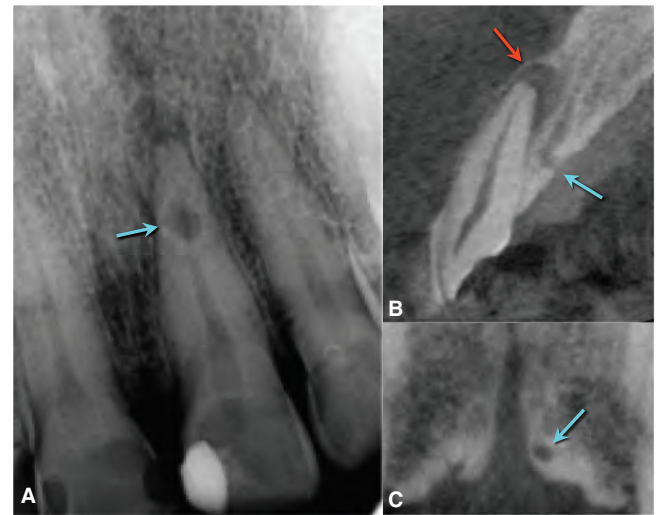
Canalis Sinuosus* mimicking the appearance of root resorption. A. Periapical radiograph of a maxillary left central incisor with recurrent caries and pulpitis showing apical radiolucency, and what appears to be root resorption in the apical third of the root (blue arrow). B. CBCT sagittal reconstruction showing the same tooth with an apical lesion (red arrow), however, without evidence of the root resorption. Instead, *canalis sinuosus* was detected. *Canalis sinuosus* is a normal anatomic variation of the anterior superior alveolar neurovascular bundle with rare manifestations in the anterior maxilla. C. CBCT coronal reconstruction showing the terminal region of the *canalis sinuosus* that is distinct from the incisive canal (blue arrow). Because of the nonmidline location, *canalis sinuosus* can mimic various pathologic lesions on conventional radiographs when superimposed on other anatomic structures, such as a tooth root in this case. (Courtesy of Dr. Daniel S. Schechter, Los Angeles, CA.)
